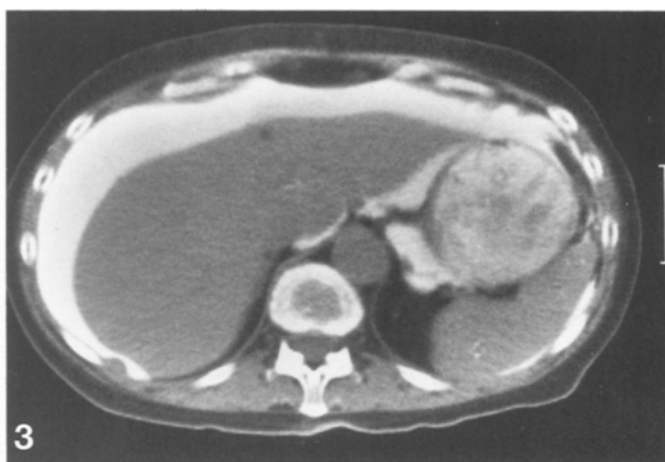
Computerized tomogram of pelvis in patients with recurrent right colon cancer. Large tumor masses 4–5 cm in diameter were found in the omental fat. Multiple smaller tumor masses 1 mm to 4 cm in diameter were found throughout the abdominal cavity that were not seen on CT scan. In this patient opacification of small bowel loops and a large amount of ascites made the tumor mass obvious
